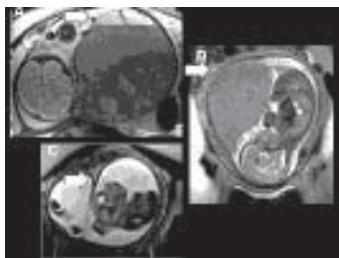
A-C, Fetal MRI and Placental pathologies. Placental hemorrhage showing placenta enlarged with mass effect on fetal head and limbs. An ill-defined hyperintensity detected in the central portion of the placenta represents hemorrhage. A fluid-fluid level is detected in the anterior aspect of the placenta and is probably secondary to the hemorrhage. 10 B, sagittal MRI demonstrates Placenta increta covering the internal os. The margins are irregular. Heterogeneity detected within the placenta is likely to represent intraplacental hemorrhage. There is invasion of the uterine myometrium. Figure 10 C is a case of amniotic band seen within the superior portion of the sac, extending from the anterior to posterior walls.
